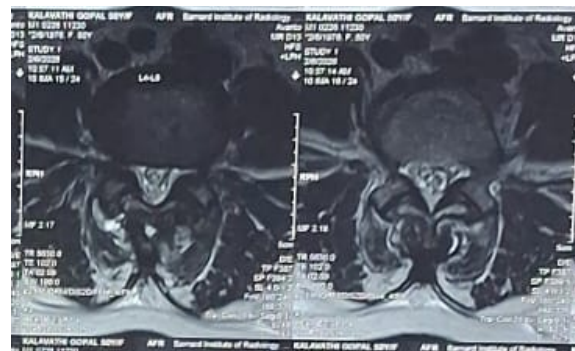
MRI Image- Axial sections at L4-L5
